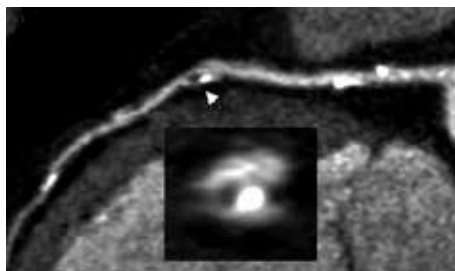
Representative CCTA Images with Napkin-ring Signs. An atherosclerotic plaque with positive remodeling, low attenuation plaque, and a napkin-ring sign in the proximal left anterior descending artery on computed tomography angiography. The boxed area indicates cross-sectional images of atherosclerotic plaque showing a napkin-ring sign.
